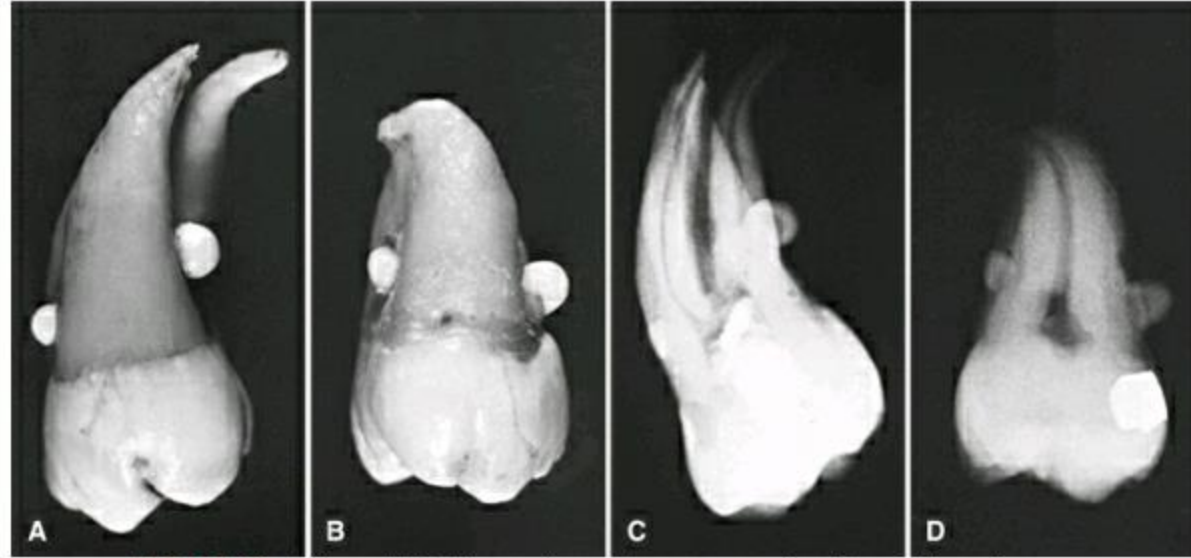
(A and B) Enamel pearls are small outgrowths of enamel and dentin in the furcation areas of teeth. (C and D) Radiographic images of the teeth in A and B. (Courtesy Dr. R. Kienholz, Dallas, Texas.)
